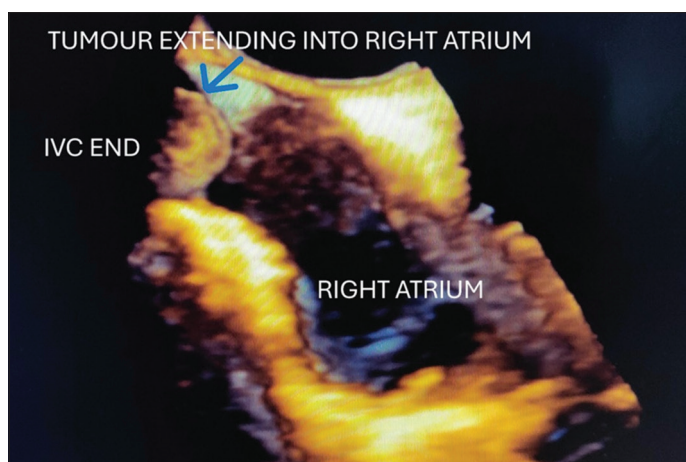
Live 3D transesophageal echocardiography bicaval view
